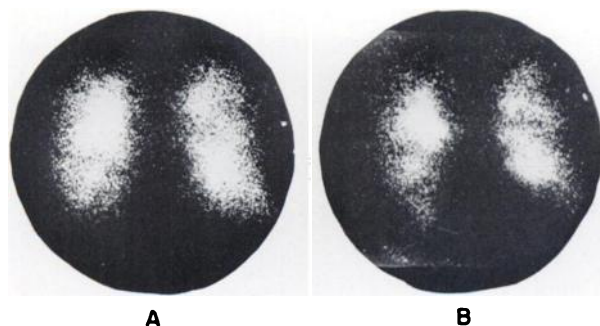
Posterior views of a patient made with (A) B.A.R.C. nebulizer, and (B) ultrasonic nebulizer.
